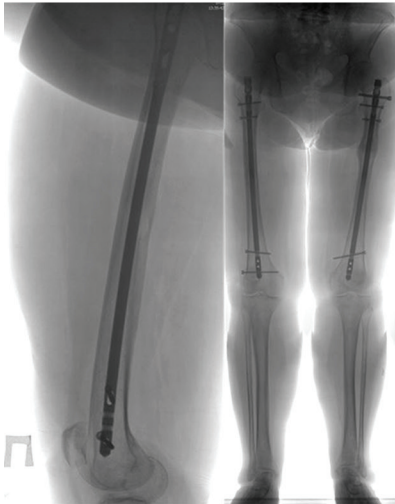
Radiographs and computed tomography scans of the femurs
